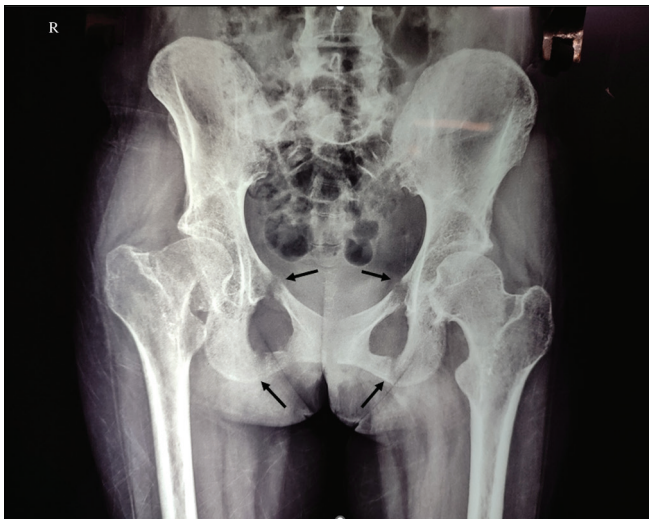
X-ray of the pelvis showing looser’s zones (arrows) in both pubic rami and undisplaced fracture in the right femoral neck
